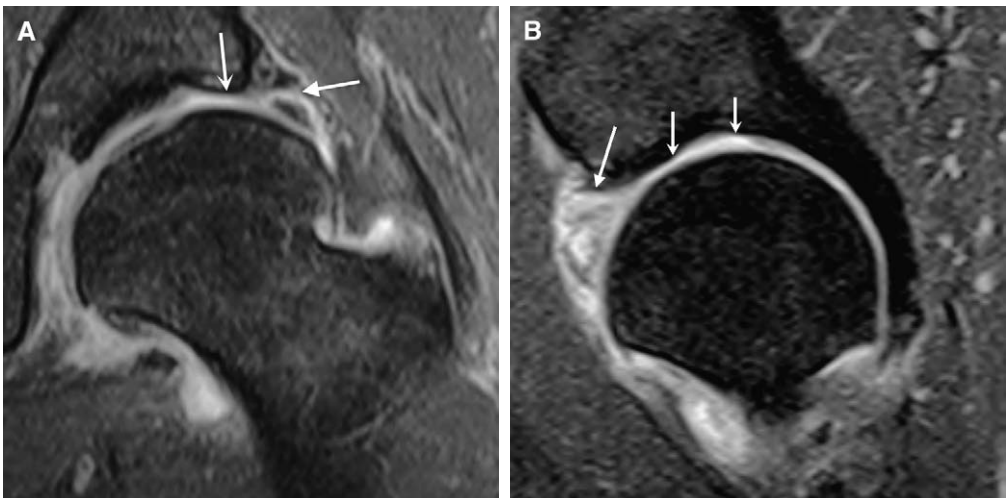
Coronal and sagittal fat-saturated T1-weighted images with intra-articular gadolinium in a patient with developmental dysplasia. A detachment is present at the base (*A* and *B*, arrows with straight heads). A large cartilage defect is present in the acetabular rim adjacent to the labral abnormality (*A* and *B*, arrows with curved heads). On the sagittal image, note the hypertrophy of the anterior labrum with a large intrasubstance collection of contrast consistent with tear.
